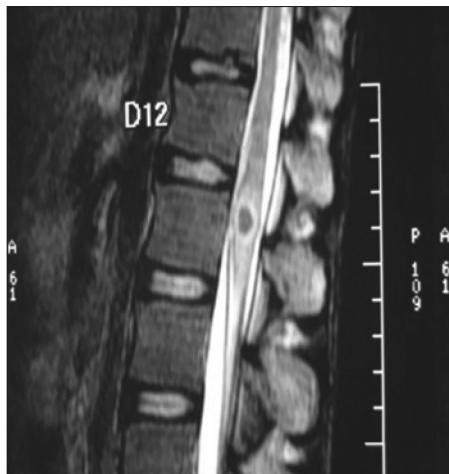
T2 weighted magnetic resonance imaging image of dorso-lumbar spine showing L1 level ring enhancing lesion with peri-lesional edema
